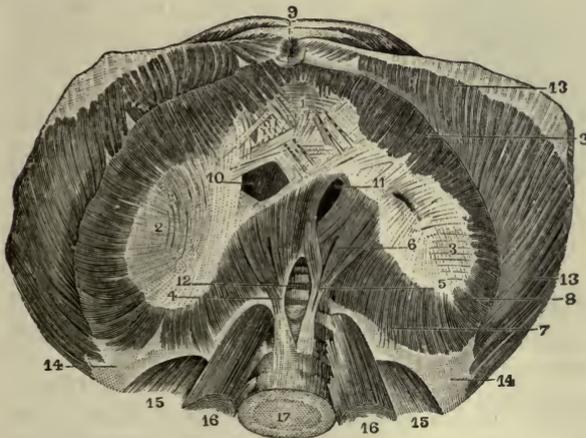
DIAPHRAGM, INFERIOR ASPECT. 1. Anterior and middle leaflet of central tendon. 2. Right leaflet. 3. Left leaflet. 4. Right crus. 5. Left crus. 6, 6. Intervals for phrenic nerves. 7. Muscular fibers, from which the ligamenta arcuata originate. 8. Muscular fibers that arise from the inner surface of the six lower ribs. 9. Fibers that arise from ensiform cartilage. 10. Opening for inferior vena cava. 11. Opening for esophagus. 12. Aortic opening. 13, 13. Upper portion of transversalis abdominis, turned upward and outward. 14. Anterior leaflet of transversalis aponeurosis. 15, 15. Quadratus lumborum. 16, 16. Psoas magnus. 17. Third lumbar vertebra.
